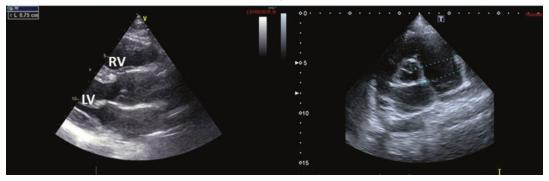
Indirect findings with pulmonary stenosis. On the left, right ventricular hypertrophy (7 mm) visualized on a parasternal long-axis view; on the right, poststenotic PA dilatation (34 mm)
